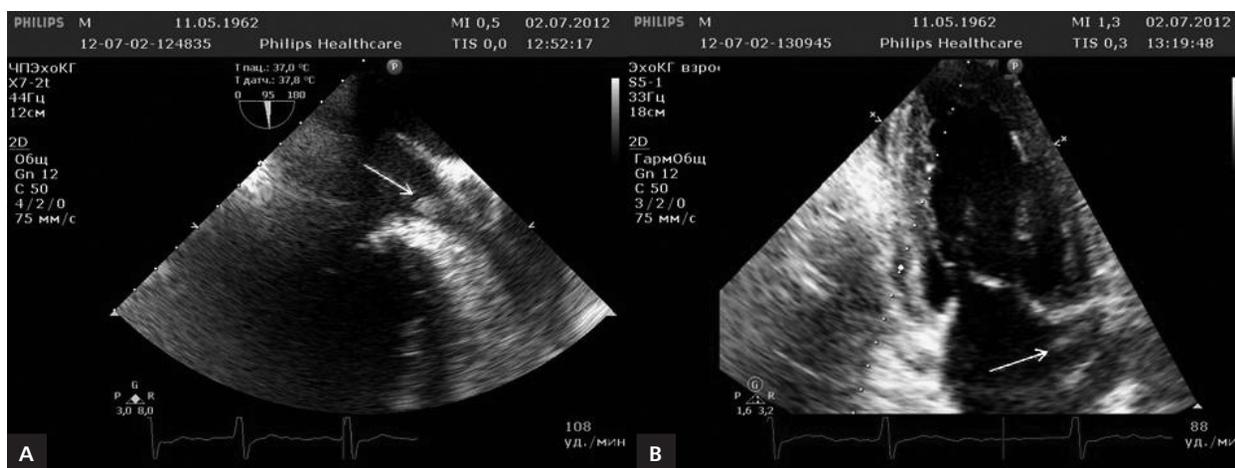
Thrombus in left atrial appendage, visualised by transthoracic (A) and transoesophageal echocardiography (B)
